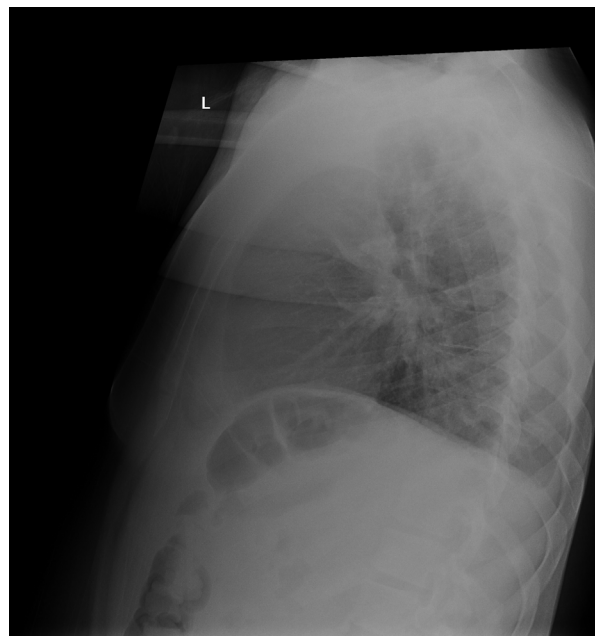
Lateral chest x-ray with retrocardiac airspace opacity.
